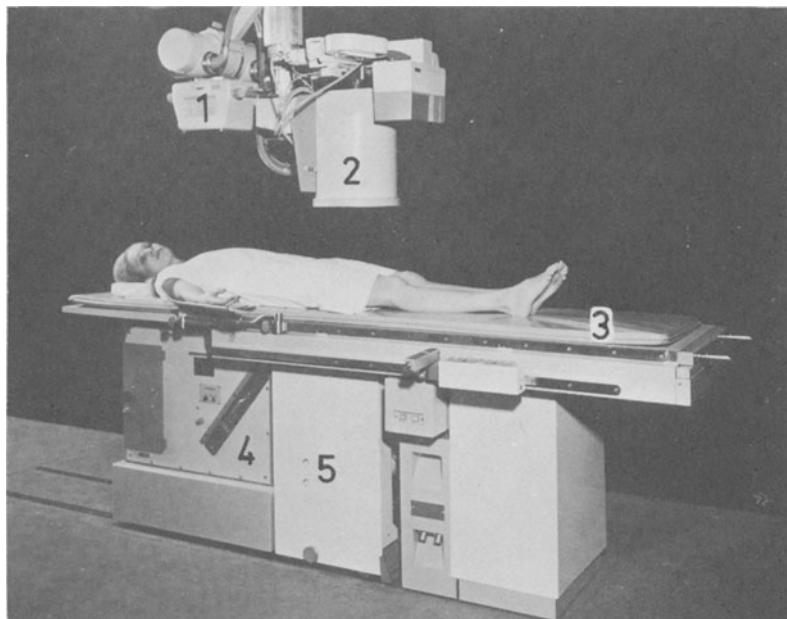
Example of a relatively simple table for angiography. The stand comprises a ceiling-suspended X-ray tube (1) and image intensifier (2) which can be placed in any position desired. The table-top (3) can be slid lengthwise over a great distance. An A.O.T. (4) and an X-ray tube (5) (for example in a tank unit) may be located under the table. A 70 mm rapid-series camera as well as a cine camera are attached to the image intensifier. A cradle, which can be rotated, can be attached to the table.
